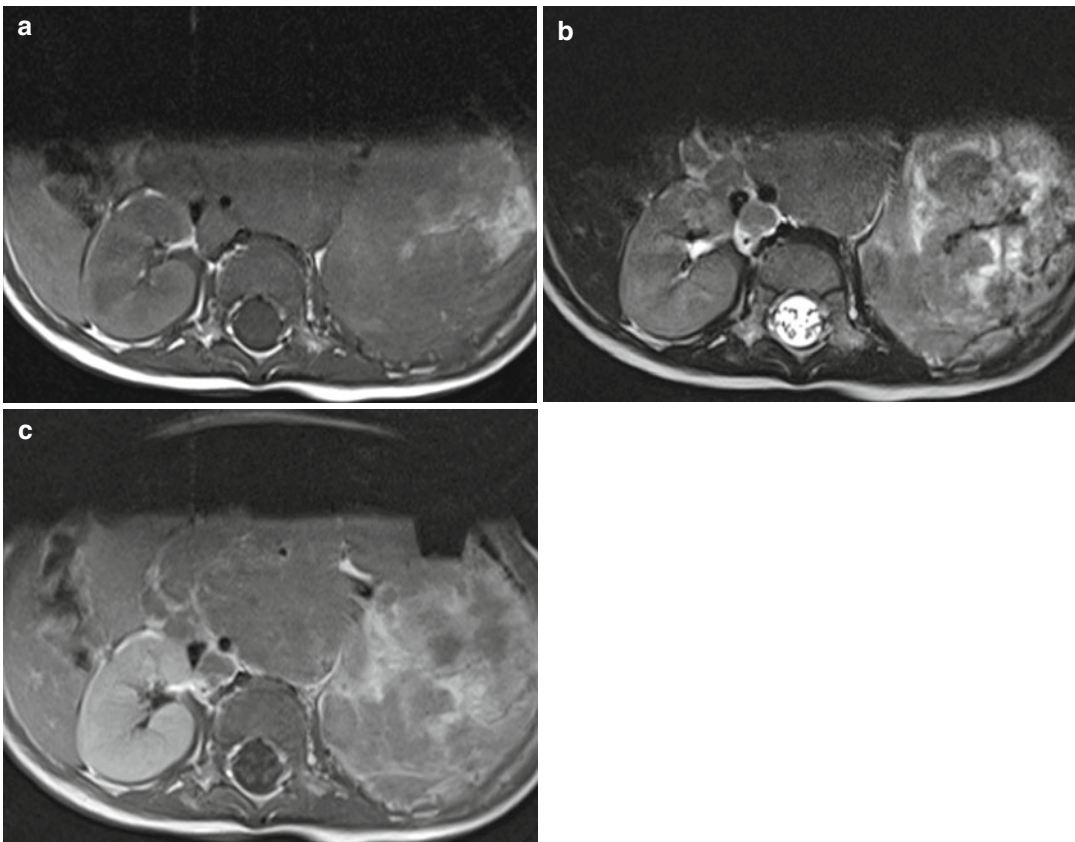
Neuroblastoma – *MR*. MR images in a 5-year-old boy with a left adrenal neuroblastoma reveal heterogeneous intermediate T1 signal (a) and mixed
